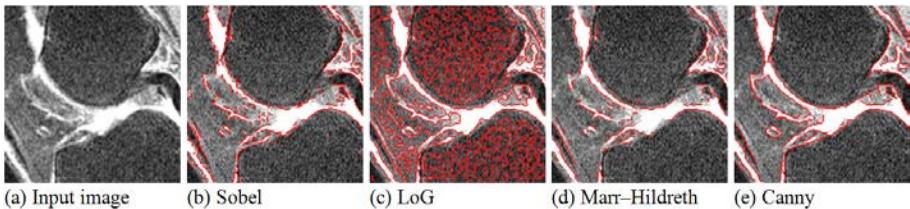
A comparison of edge detection approaches. (a) The input image (a region of interest from the knee MRI in Fig. 17.11); (b) edges produced by the Sobel detector; (c) zero crossings of the convolution of the image with the Laplacian of Gaussian operator; (d) edges produced by the Marr–Hildreth detector, i.e. a subset of the zero crossings that have gradient magnitude above a threshold; (e) edges produced by the Canny detector.
